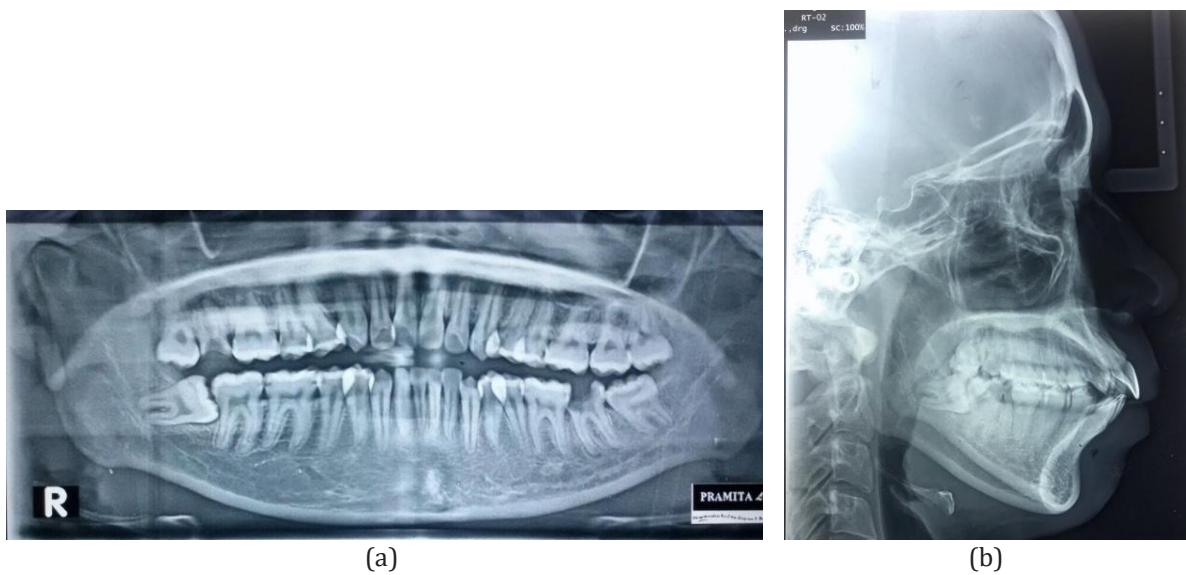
Pretreatment radiograph examination. (a) Panoramic radiograph, (b) Lateral cephalogram.
